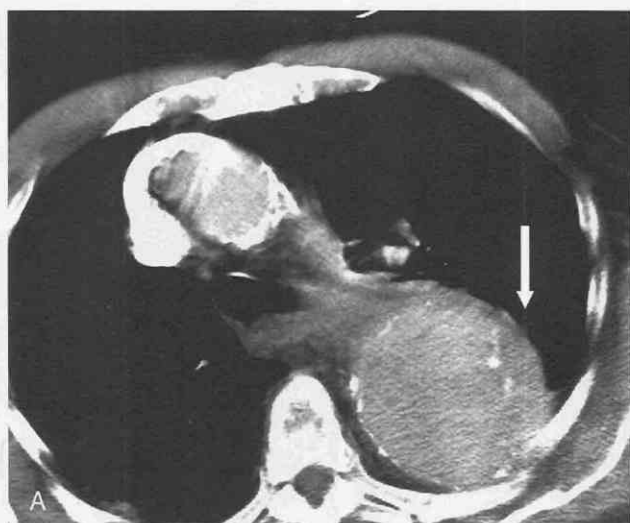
A, Axial CT scan shows leaking descending aortic aneurysm, with soft tissue extending beyond the mural calcification (arrow). B, Axial CT scan at a level inferior to that in A shows extension of the leak into the mediastinum (arrow).
